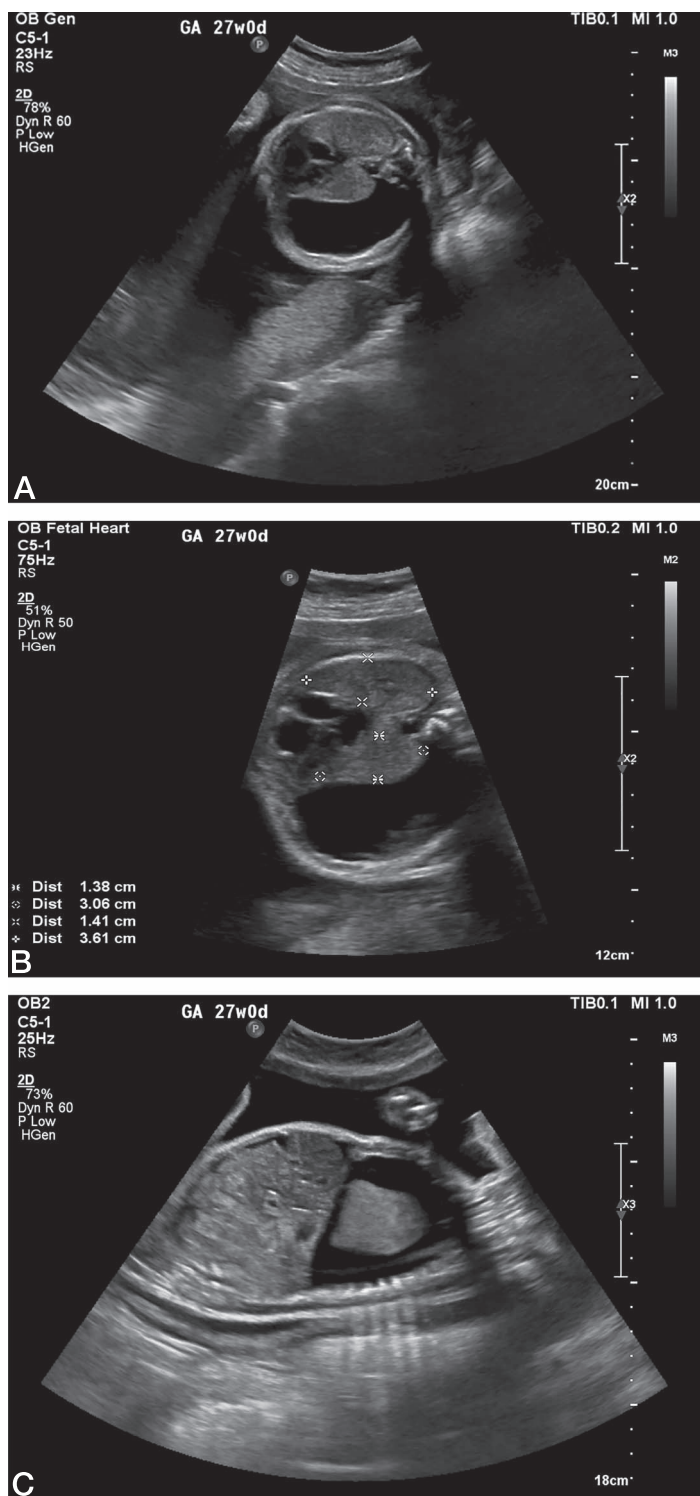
Ultrasound images obtained prior to shunting. (A) Pleural effusion seen. (B) Small ipsilateral lung, heart shift. (C) Sagittal view for the chest pleural effusion seen. GA: gestational age.
